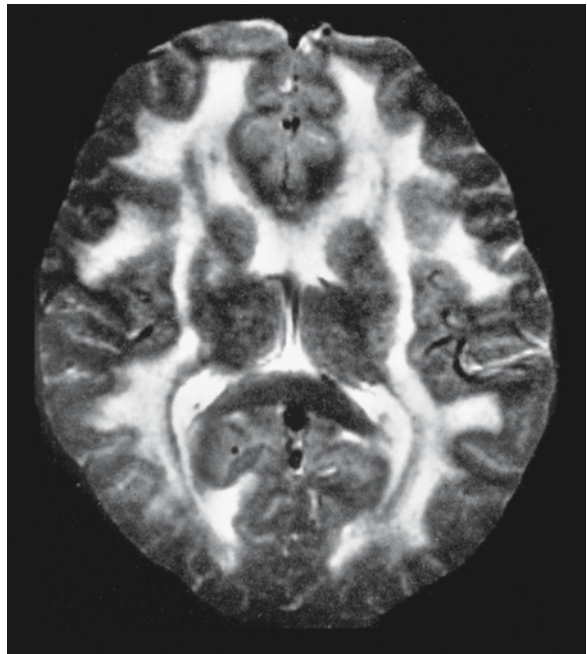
A 17-year-old patient with MNGIE. Note the diffusely high signal intensity of the cerebral white matter on this T₂-weighted MR image. The corpus callosum, internal capsule, and optic radiation are spared. From Simon et al. (1990), with permission
